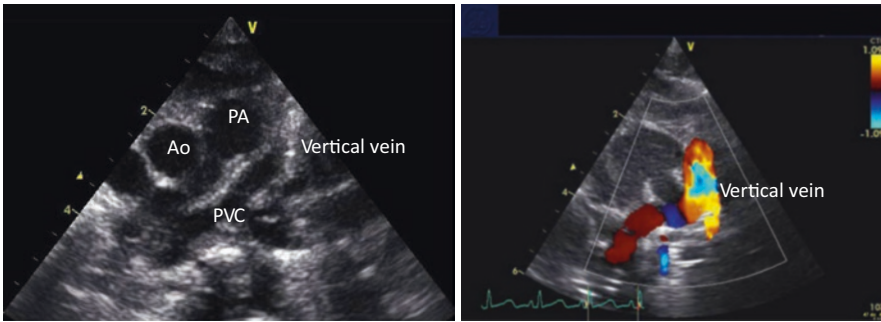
High left parasternal: Pulmonary vein collector (PVC) and vertical vein (red flow, right-sided picture)
